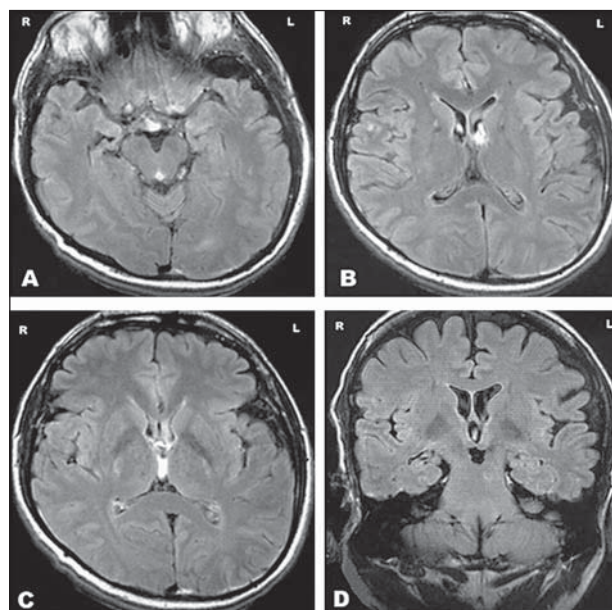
(A, B, C, D). Axial and coronal FLAIR images revealing left frontotemporal opercular atrophy on cranial MRI.
